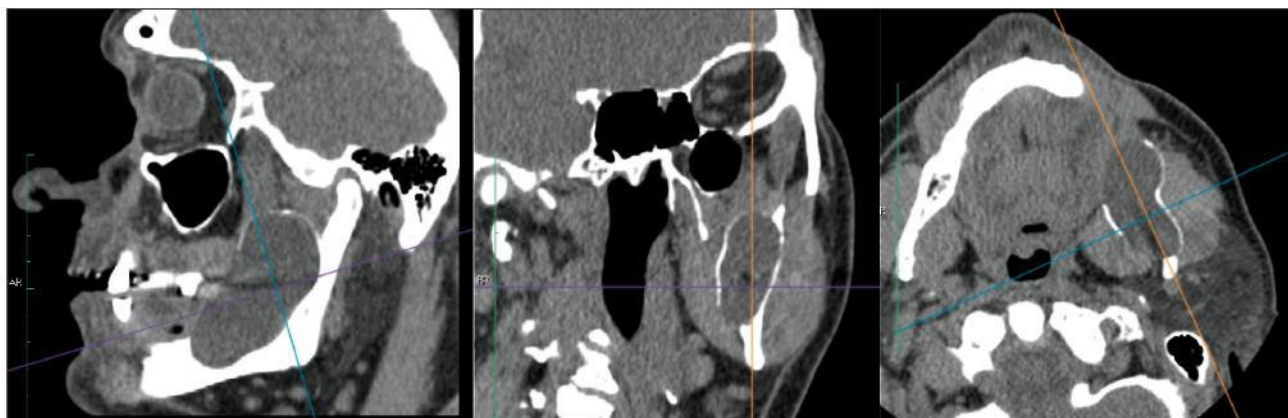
CT profiles with visible radicular cyst. Pre-treatment condition.
